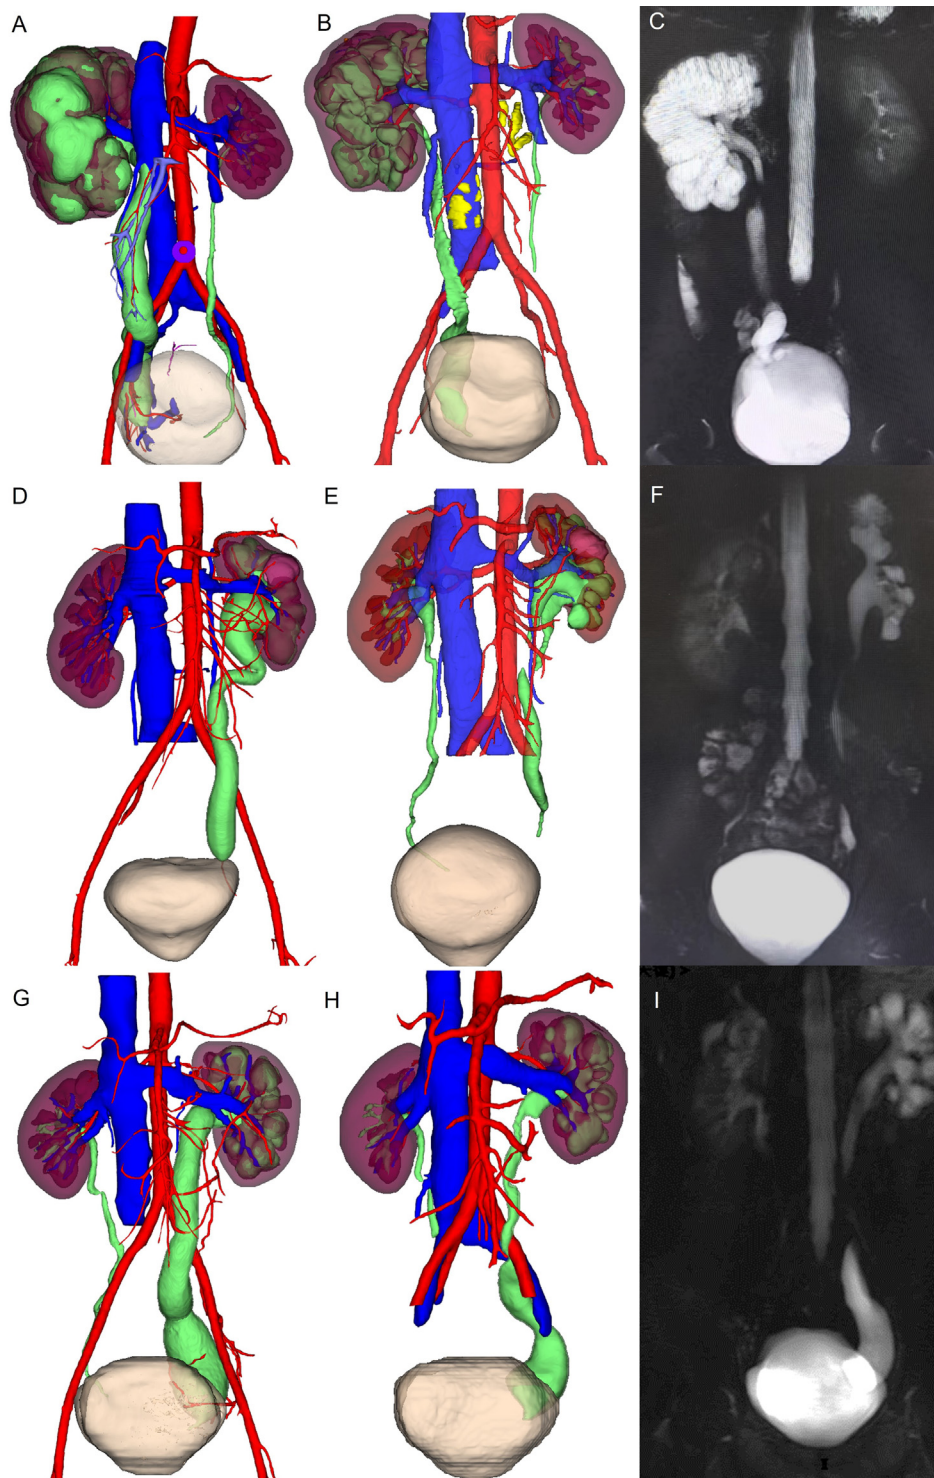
Preoperative and postoperative imaging for three patients primary obstructive megaureter who underwent endoscopic treatment. (A, D, G) Preoperative and (B, E, H) postoperative three-dimensional computed tomography urography images. (C, F, I) Postoperative cine magnetic resonance urography images.
